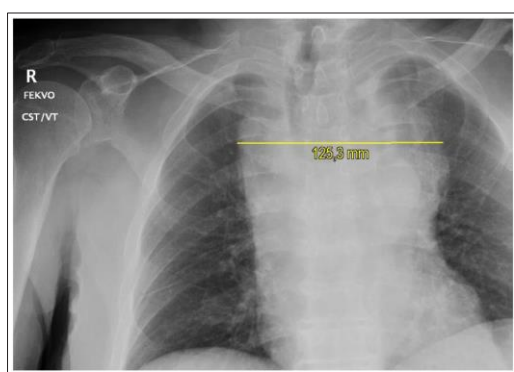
The anteroposterior chest X-ray showing extreme mediastinal widening
